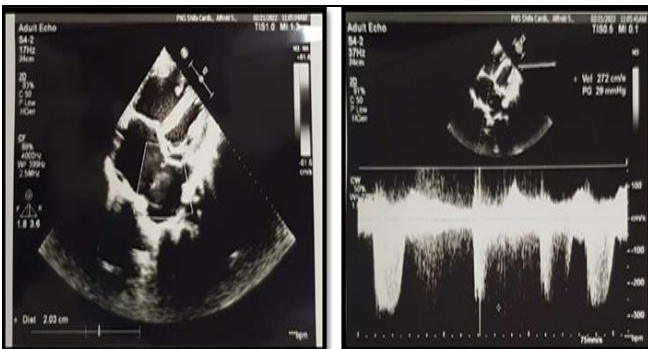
2D Echocardiograph showing ASD Secundum size measuring 20mm
